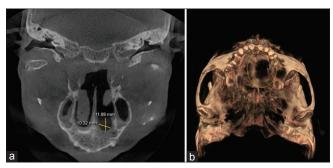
(a) Axial and (b) 3D Cone Beam CTview revealed a well-defined radiolucency on the bhard palate measuring 11.89×10.32 mm
